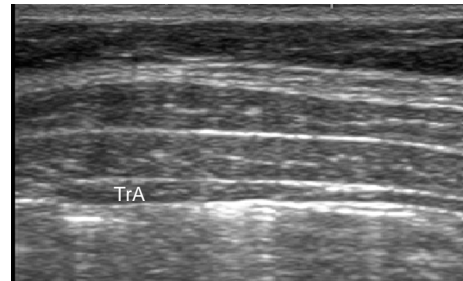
Ultrasound scan of the lateral abdominal muscles, indicating transversus abdominis (TrA), which is the deepest muscle.
